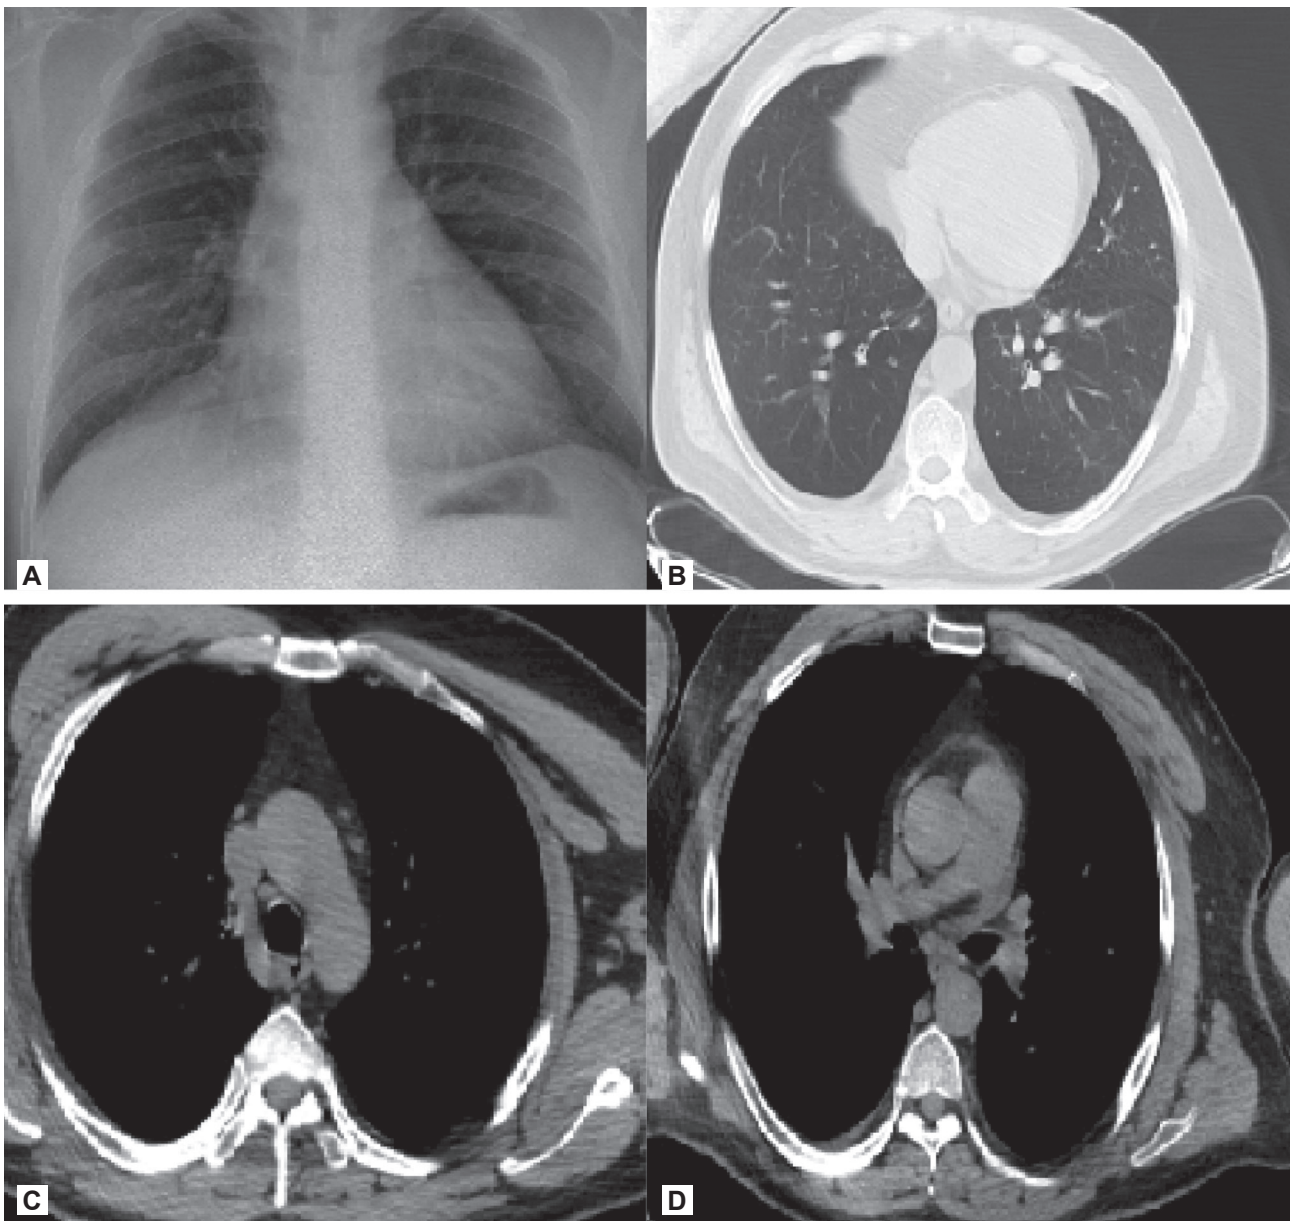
A) posteroanterior chest x-ray, B-C-D) non-contrast thorax computed tomography (nearly normal radiological imaging were found at the tenth month after diagnosis).
